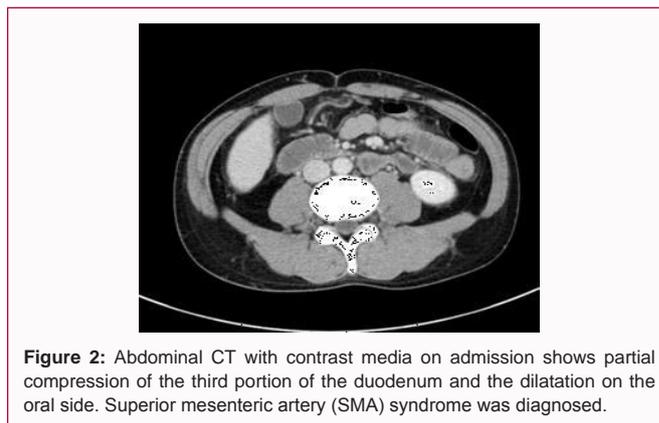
Abdominal CT with contrast media on admission shows partial compression of the third portion of the duodenum and the dilatation on the oral side. Superior mesenteric artery (SMA) syndrome was diagnosed.
